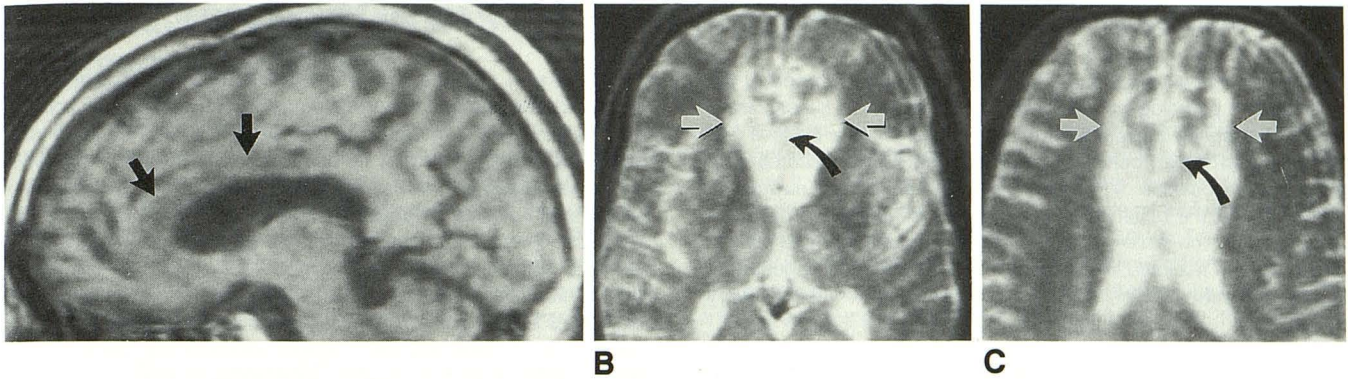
Midline sagittal T1-weighted MR image, SE 500/30, shows reduced signal in genu and body of corpus callosum (arrows). B and C, Proton density, SE 2000/60 (B), and T2-weighted, SE 2000/120 (C), MR images show associated bright signal in medial frontal lobe cortex bilaterally (straight arrows) and in corpus callosum (curved arrows).
